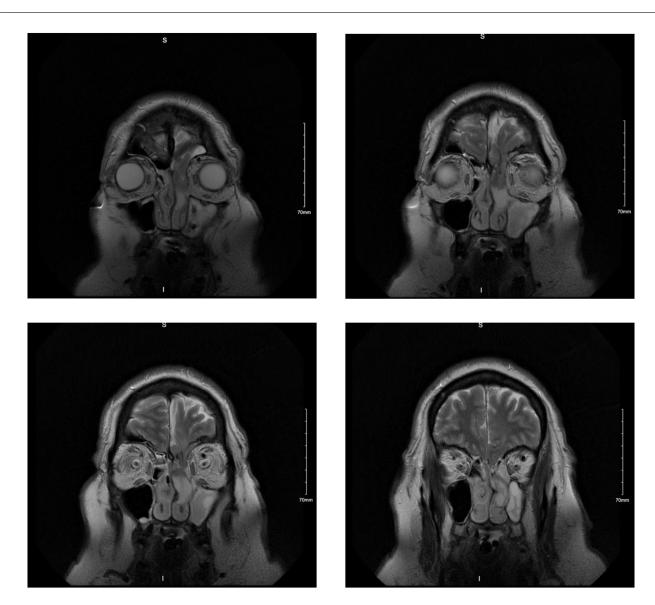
T2-weighted coronal images were obtained from MRI of the head, labeled above from anterior to posterior. The figures show herniation of the left frontal lobe brain parenchyma into the left frontal sinus and into the superior aspect of the left nasal cavity.
